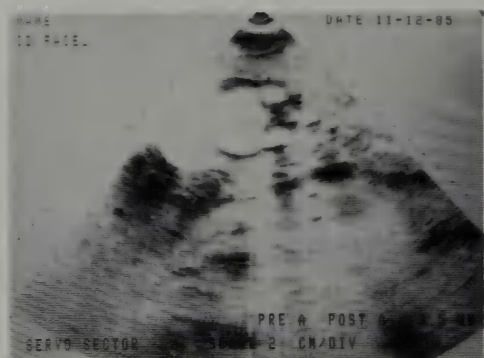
Ultrasonography. Fetal skull and eye orbits are identified.
